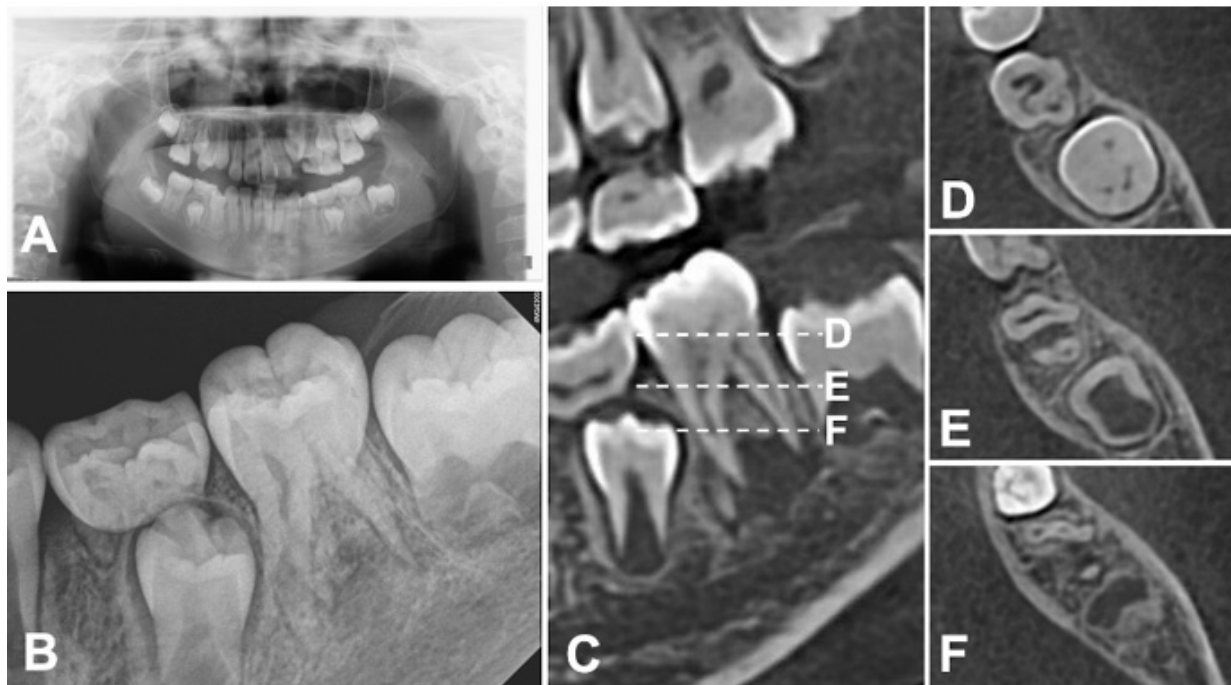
Preoperative Radiographs. (A) Initial panoramic radiograph. (B) Periapical radiograph showing molar-incisor malformation in the left mandibular first molar. (C) Sagittal CBCT view of the maxillary molar. Dashed lines D, E, and F indicate the respective levels of the apical, middle, and coronal axial image. (D) Axial CBCT image (coronal area), showing complex internal anatomy. (E) Axial CBCT image (middle area), revealing five canals in the left mandibular first molar: three mesiobuccal, two distal. (F) Axial CBCT image (apical area). Widening of the periodontal ligament (PDL) space is observed at the distal root apex.
